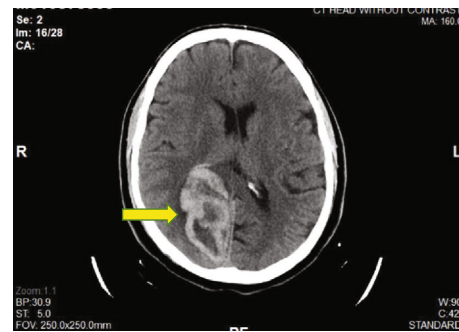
A CT head without contrast (two days after discharge): yellow arrow - a hemorrhagic right occipital infarct.
